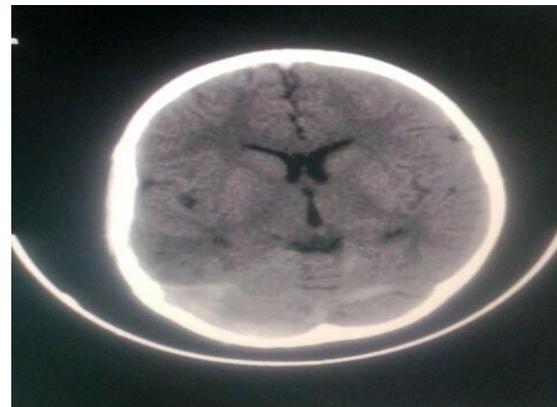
CT scan showing a minimal subdural haematoma of 7mm in the Right occipital region.
